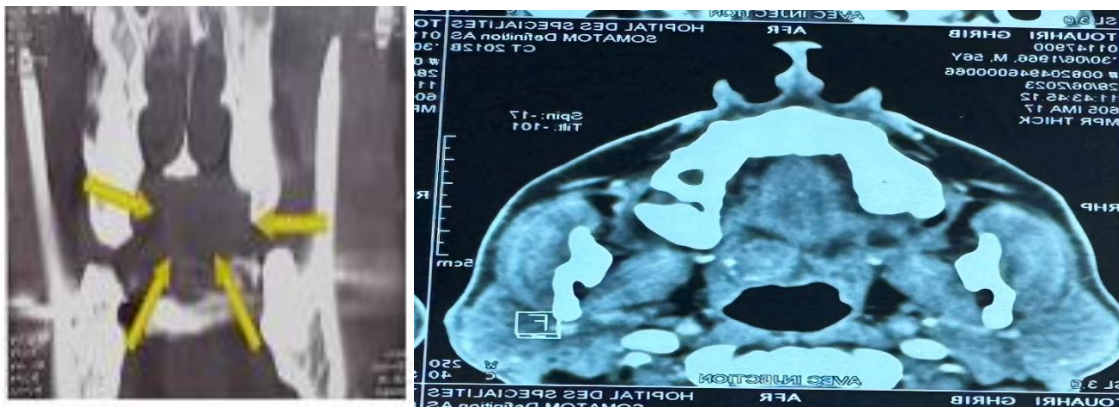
Axial and coronal maxillofacial CT sections showing a Tissue process, well limited to the soft palate.
